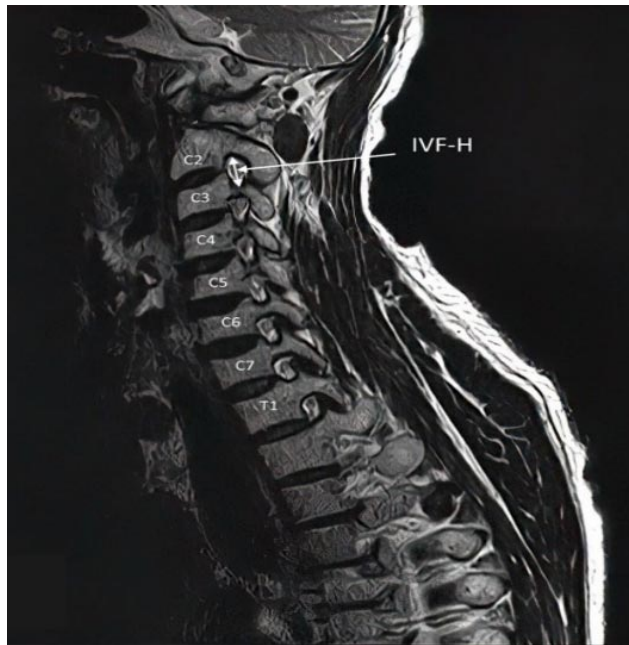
Parasagittal T2- weighted MRI image of the cervical spine showing IVF-H.
